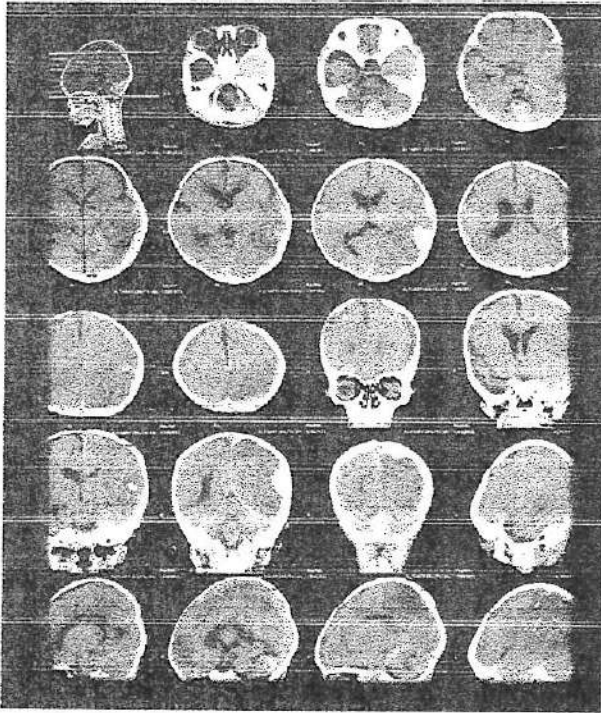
Head CT scan on September 11th 2018 showed communicating hydrocephalus
